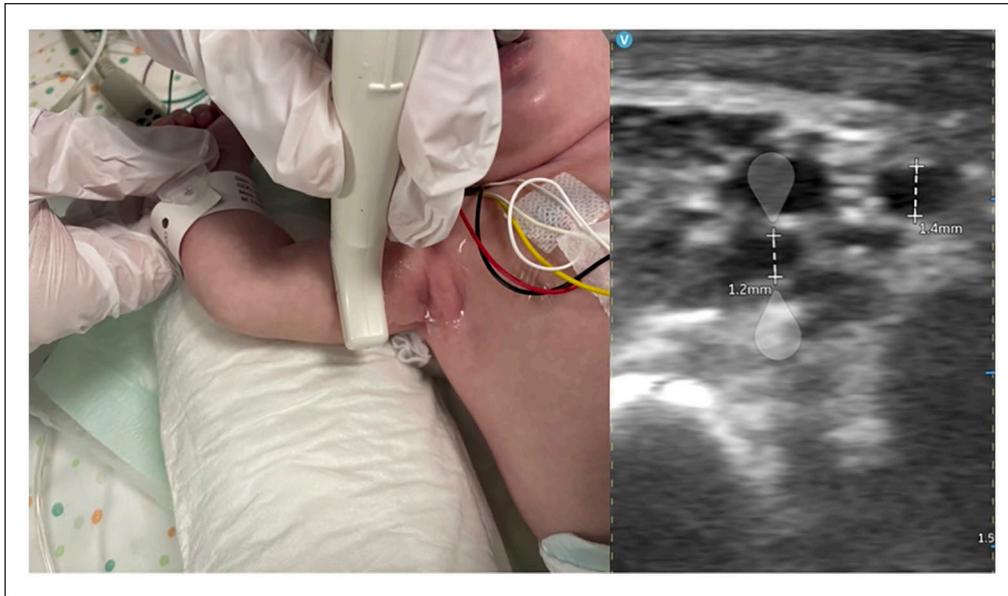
Ultrasound evaluation of deep veins of the arm at the mid-portion of upper arm (green zone according to Dawson) (scan 1): visualization of the brachial vein (diameter 1.2 mm) and of the basilic vein (diameter 1.4 mm).
